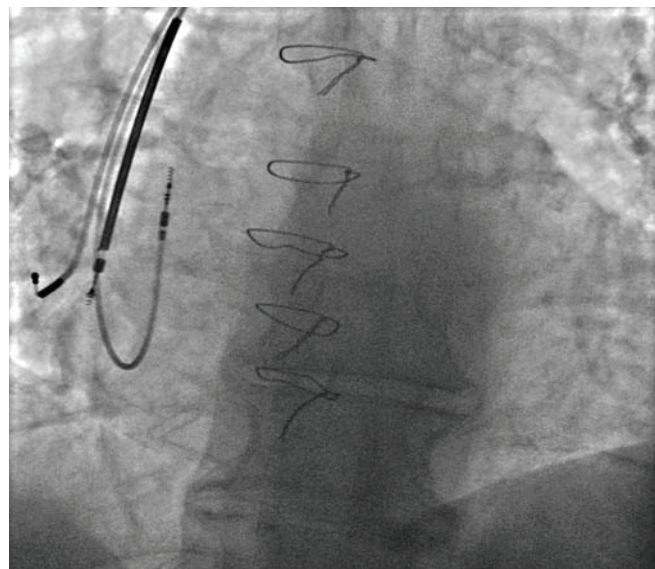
Displaced leads confirmed by x-ray
